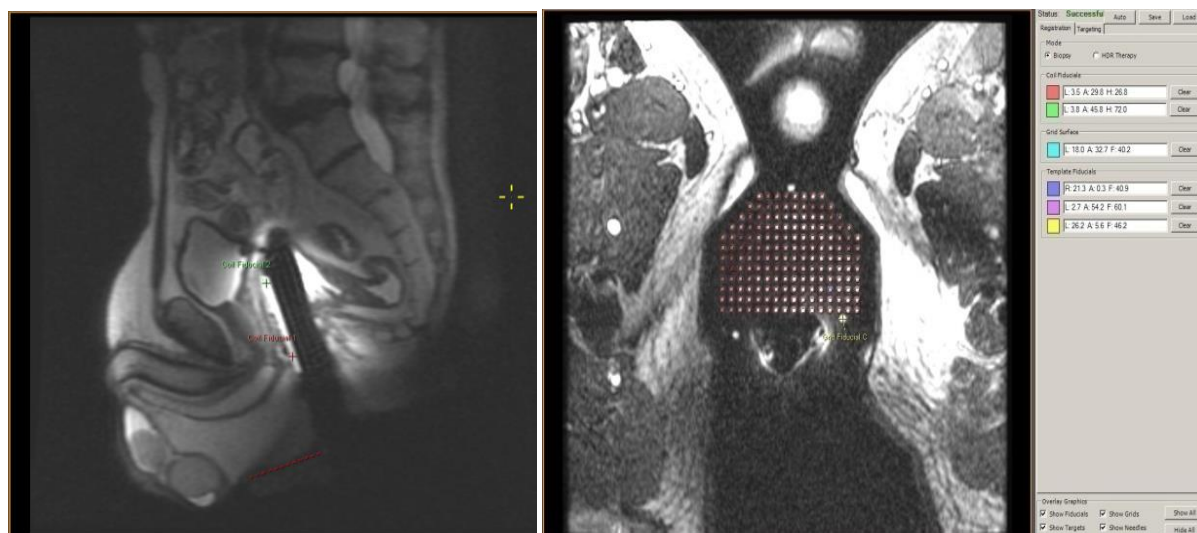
MRI scout images for the purpose of endorectal coil and perineal template registration allowing stereotactic navigation of the needles. Each hole in the template has unique coordinates, allowing needle tracking.
